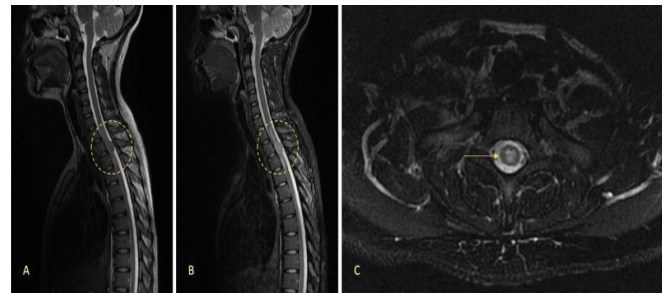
MRI study at diagnosis showing an intramedullary solid lesion with a maximum diameter of 20.5 mm, extending from the medium level of T2 to the medium level of T3 vertebrae, with an extent infiltration of spinal cord and subarachnoid space. Sagittal vision with a T2-weighted sequence (A) and a short-T1 inversion recovery (STIR) sequence (B). Axial vision with a T2-weighted sequence (C).
